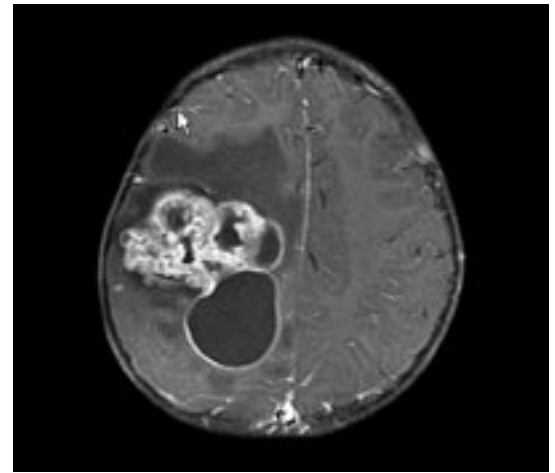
Ependymoma in an 8-month-old girl who presented with lethargy and enlarged head circumference. MRI demonstrated a large, multicystic, heterogeneously enhancing mass in the left frontal lobe.
